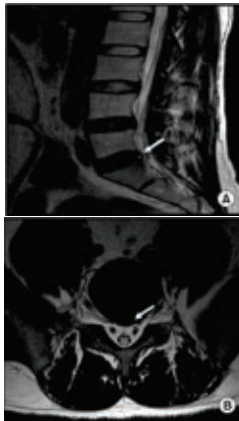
Magnetic resonance images of high intensity zone (HIZ), (A) The sagittal T2-weighted magnetic resonance image showing a HIZ (arrow) within the posterior annulus at L5-S1, (B) Thaxial T2-weighted magnetic resonance image shows a HIZ (arrow) within the posterior annulus at L5-S1
